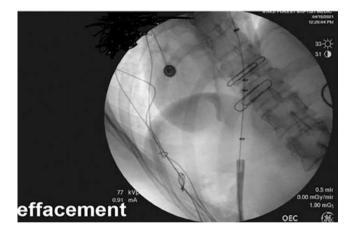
Radiographic markers identifying the lower esophageal sphincter and the diaphragmatic hiatus
